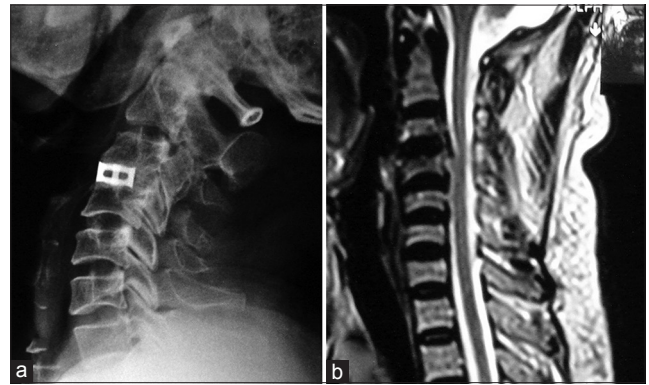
(a) X-ray of the cervical spine lateral view showing titanium cage *in situ* with good and solid bony fusion at C3–C4 level, note the posterior osteophytes and ossified ligamentum, (b) Magnetic resonance imaging T2-weighted image showing mild cord compression and calcified ligamentum
